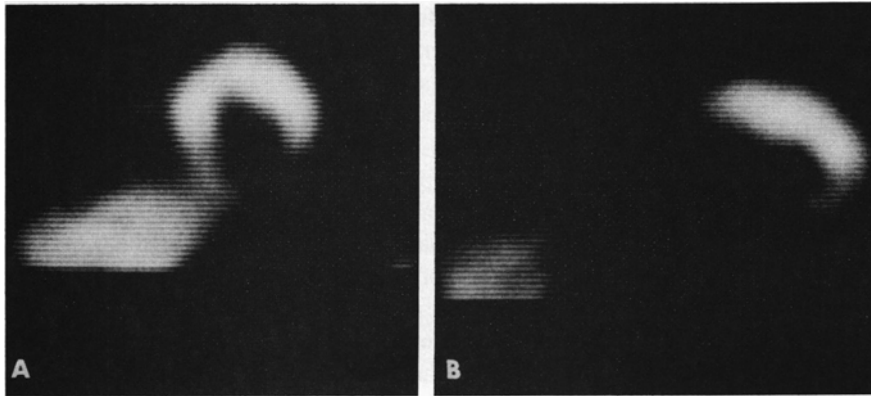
SPECT images of decreased [^{99m}Tc] TBI distribution in patient's posterior wall. Cucumber (short axis) yields high contrast image with minimal liver interference. A sagittal (long axis) slice highlights posterior wall defect.
